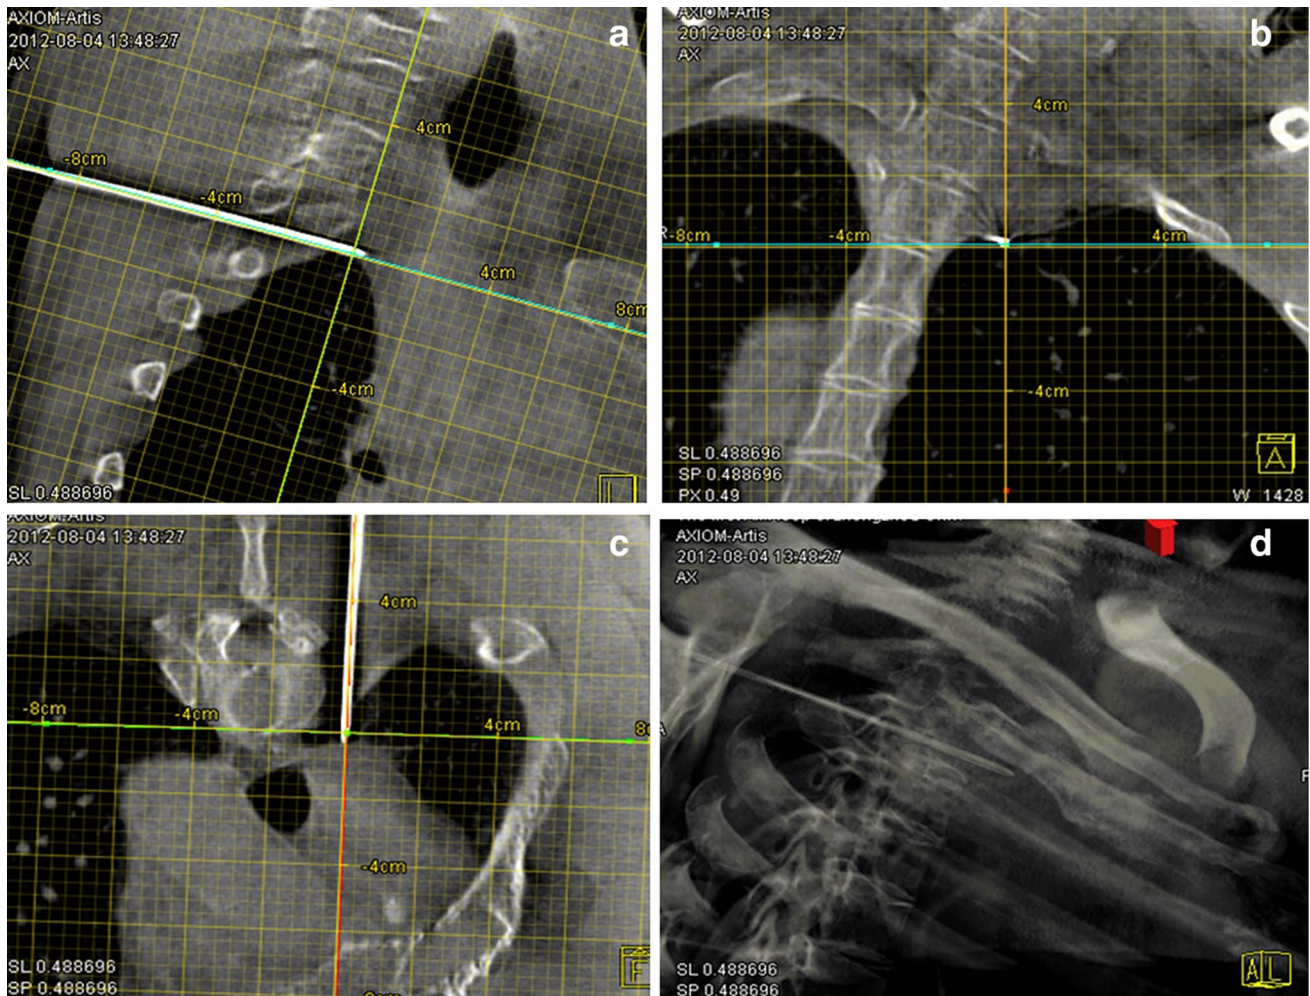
CBCT scan confirmed the needle position in multiplanar (a–c) and volume-rendering (d) images
